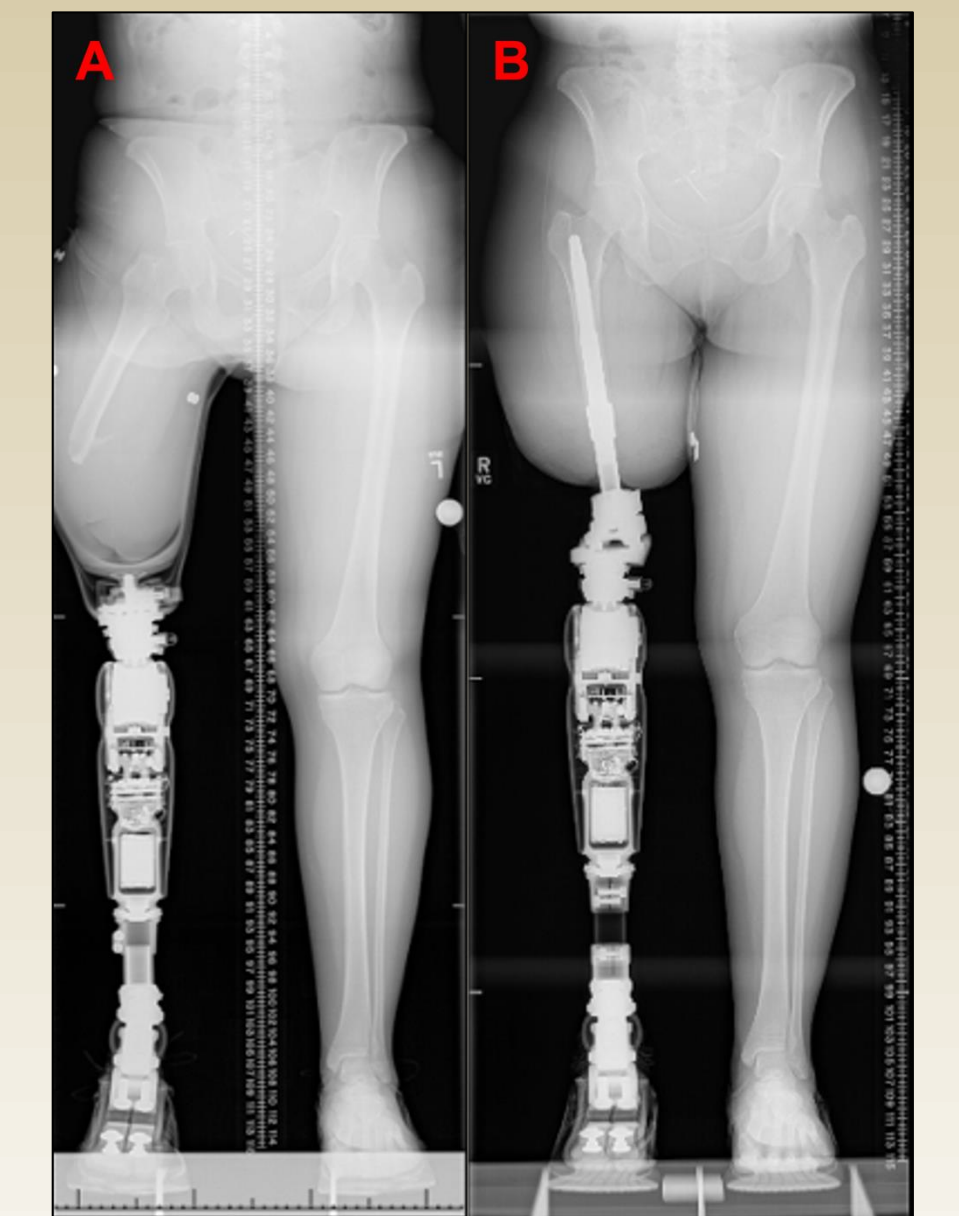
Standing radiograph of participant with socket (left, A) and bone-anchored limb (right, B)
